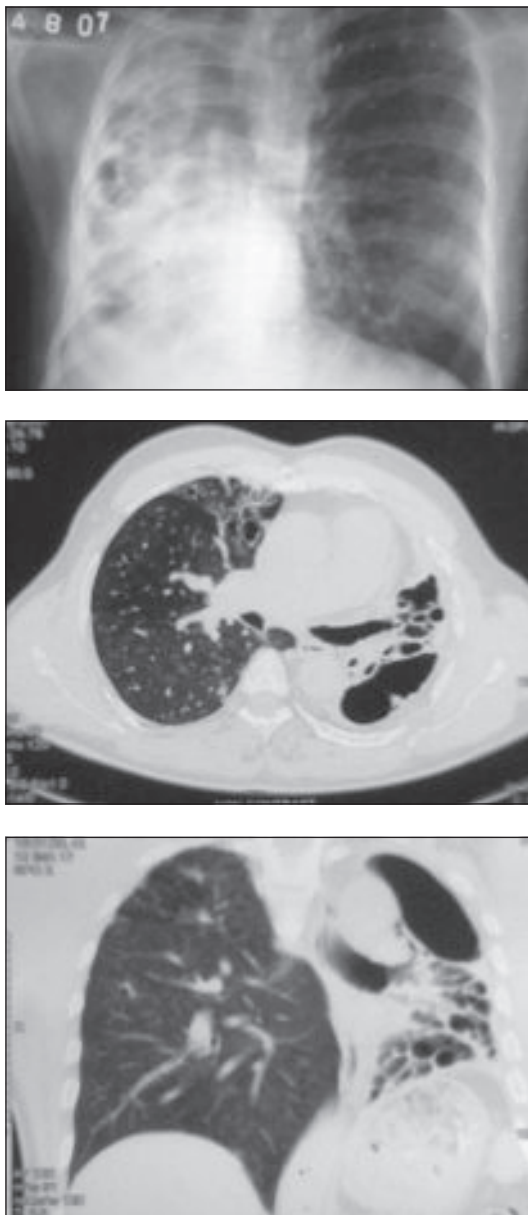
Chest x-ray and CT scan of Destroyed lung.
